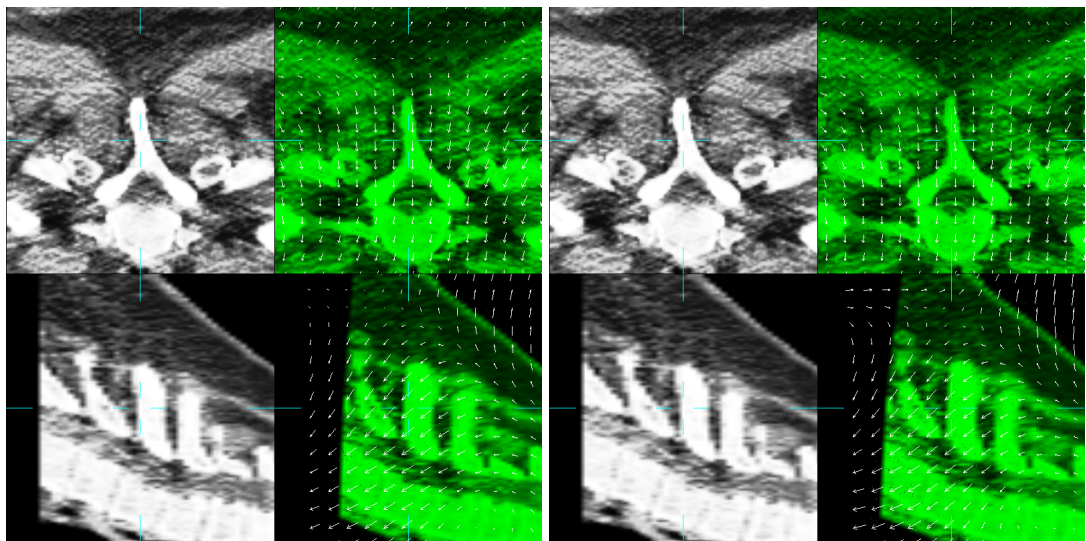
Rigid plus NRR results with changing step size using 1 step. Fixed CT images in grey colourscale and floating CT images in green colourscale.
